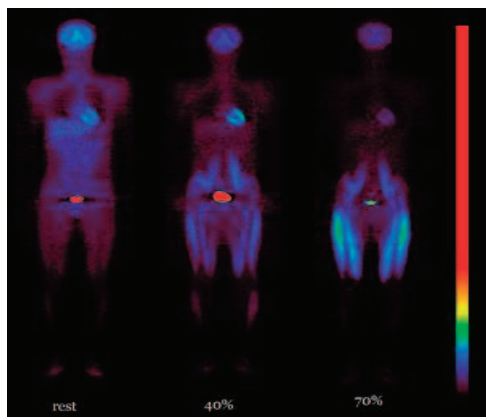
Whole-body coronal PET images with regions of interest (ROIs) analysis settings. Images are shown at rest, and 40% and 70% $\text{VO}_{2\text{max}}$ exercise workloads from left to right, respectively. High accumulation of [^{18}F]FDG was observed in the thigh muscles from rest to 40% and 70% $\text{VO}_{2\text{max}}$ workloads.
